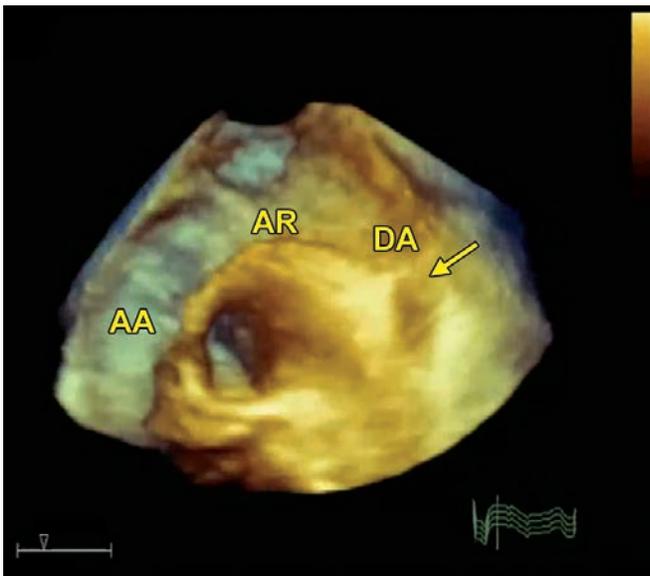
Three dimensional echocardiogram, suprasternal view, (AA: Ascending aorta; AR: Aortic arch; DA: Descending aorta stent [arrow]).
